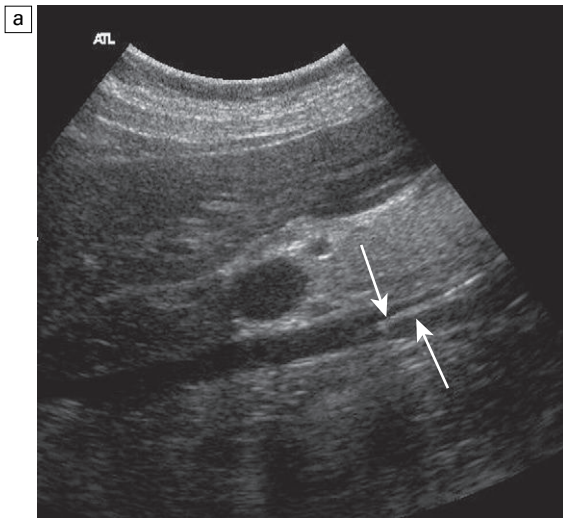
(a) Real time image of an IVC containing a filter in the lower segment; (b) colour doppler image of the same patient with a caval filter. The change in colour reflects the changing Doppler angle as the blood flows through the sector scan.
